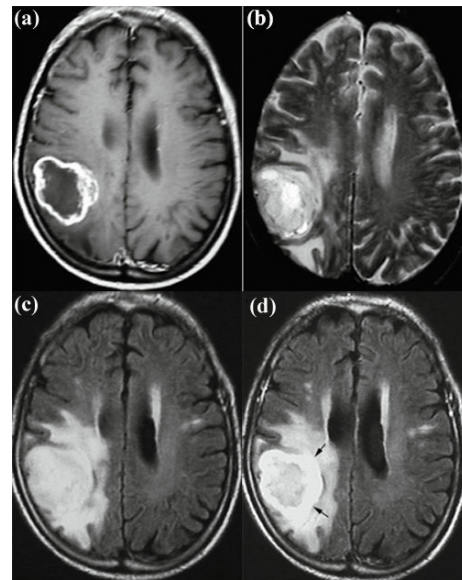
The same brain imaged with different MRI sequences. (a) T_1 -weighted. (b) T_2 -weighted. (c) FLAIR. (d) FLAIR with contrast enhancement. *Liu et al., Tsinghua Sci. Technol.* 19(6): 578–595 (2014).
